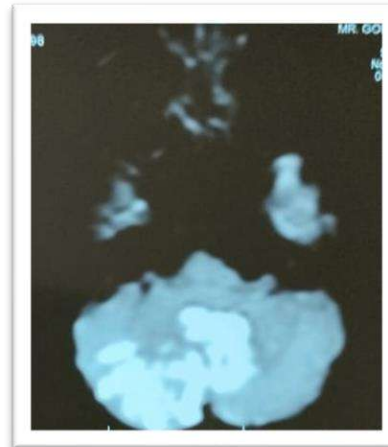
MRI brain T1 image showing hypointense lesion occupying both sides of cerebellum.
